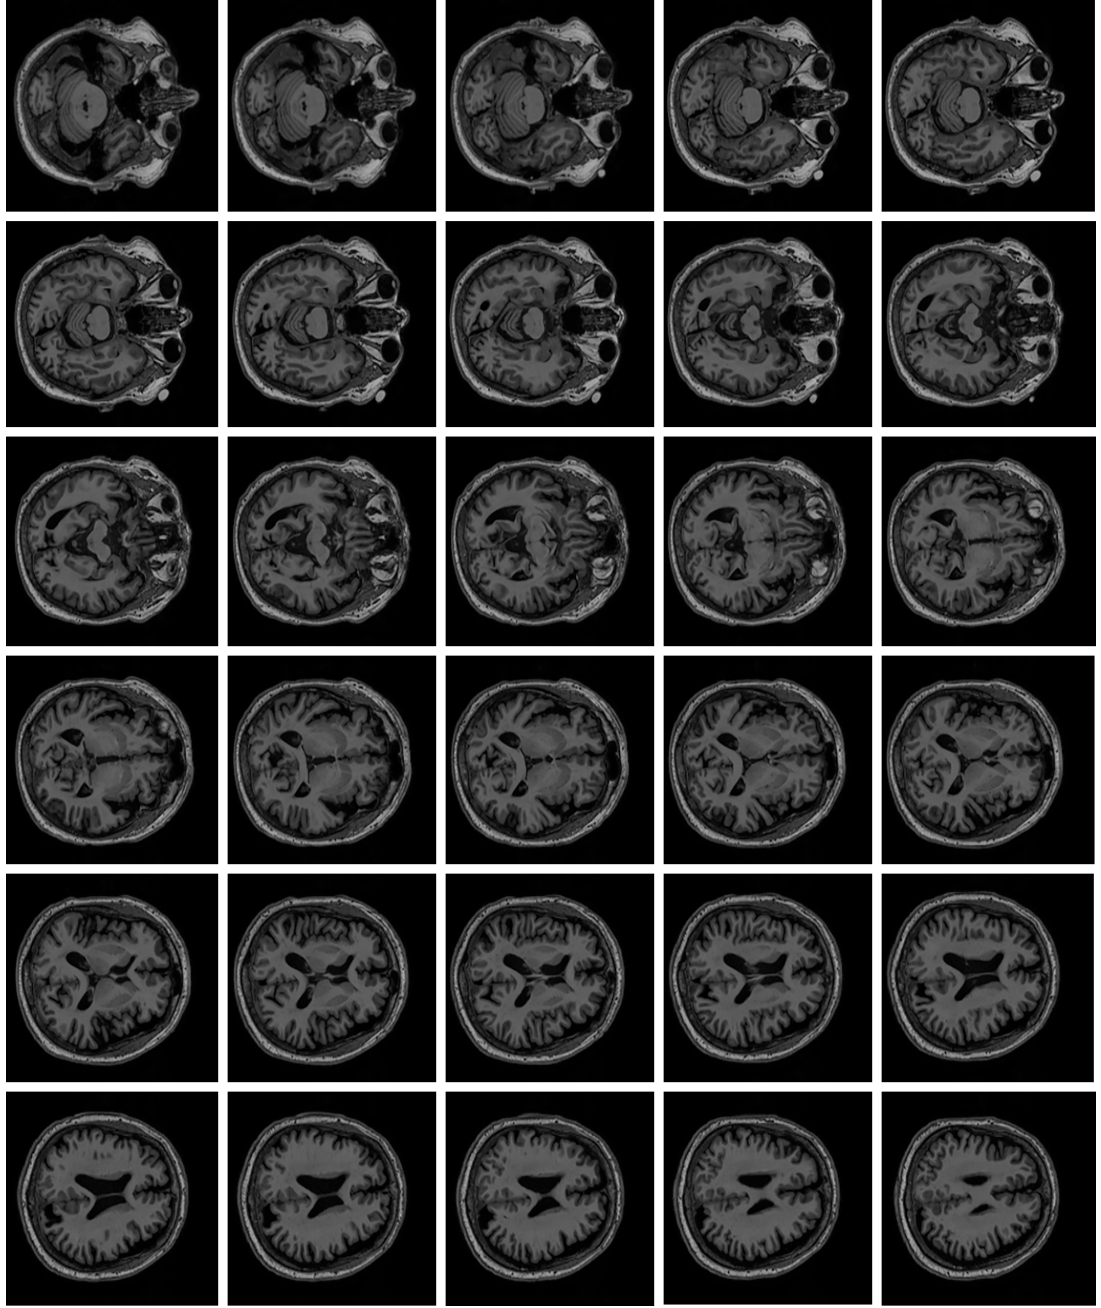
Slices of MRI volume of patient 002'S'0816, diagnosed with Alzheimer's disease. MRI volume used in the experiments consists of 60 slices, out of which every other slice is shown in this figure
